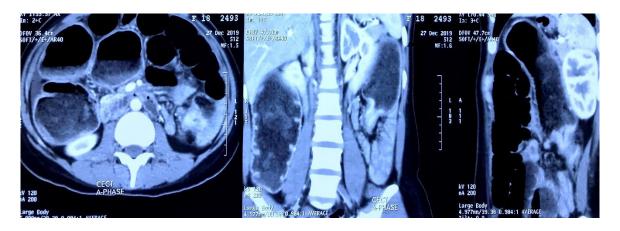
Image CT\_2: Axial, Coronal and Sagital view of the growth in the desecding colon.
